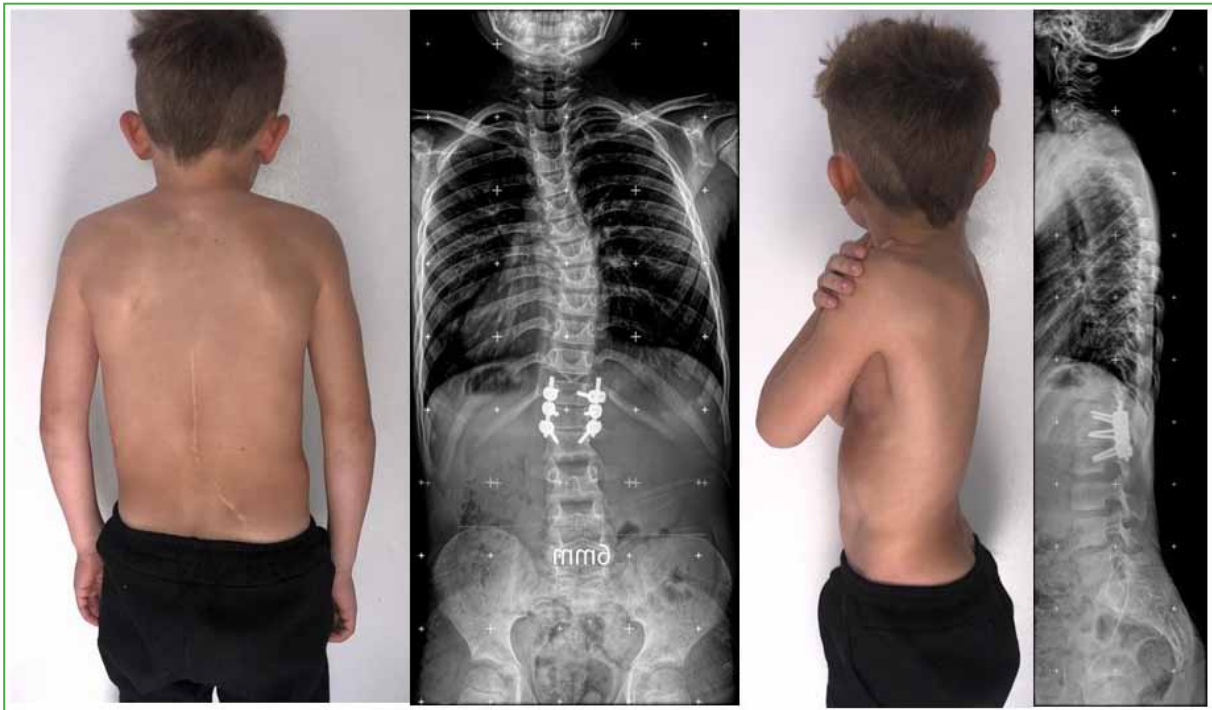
Clinical and radiographic appearance after 7 years of follow-up.
